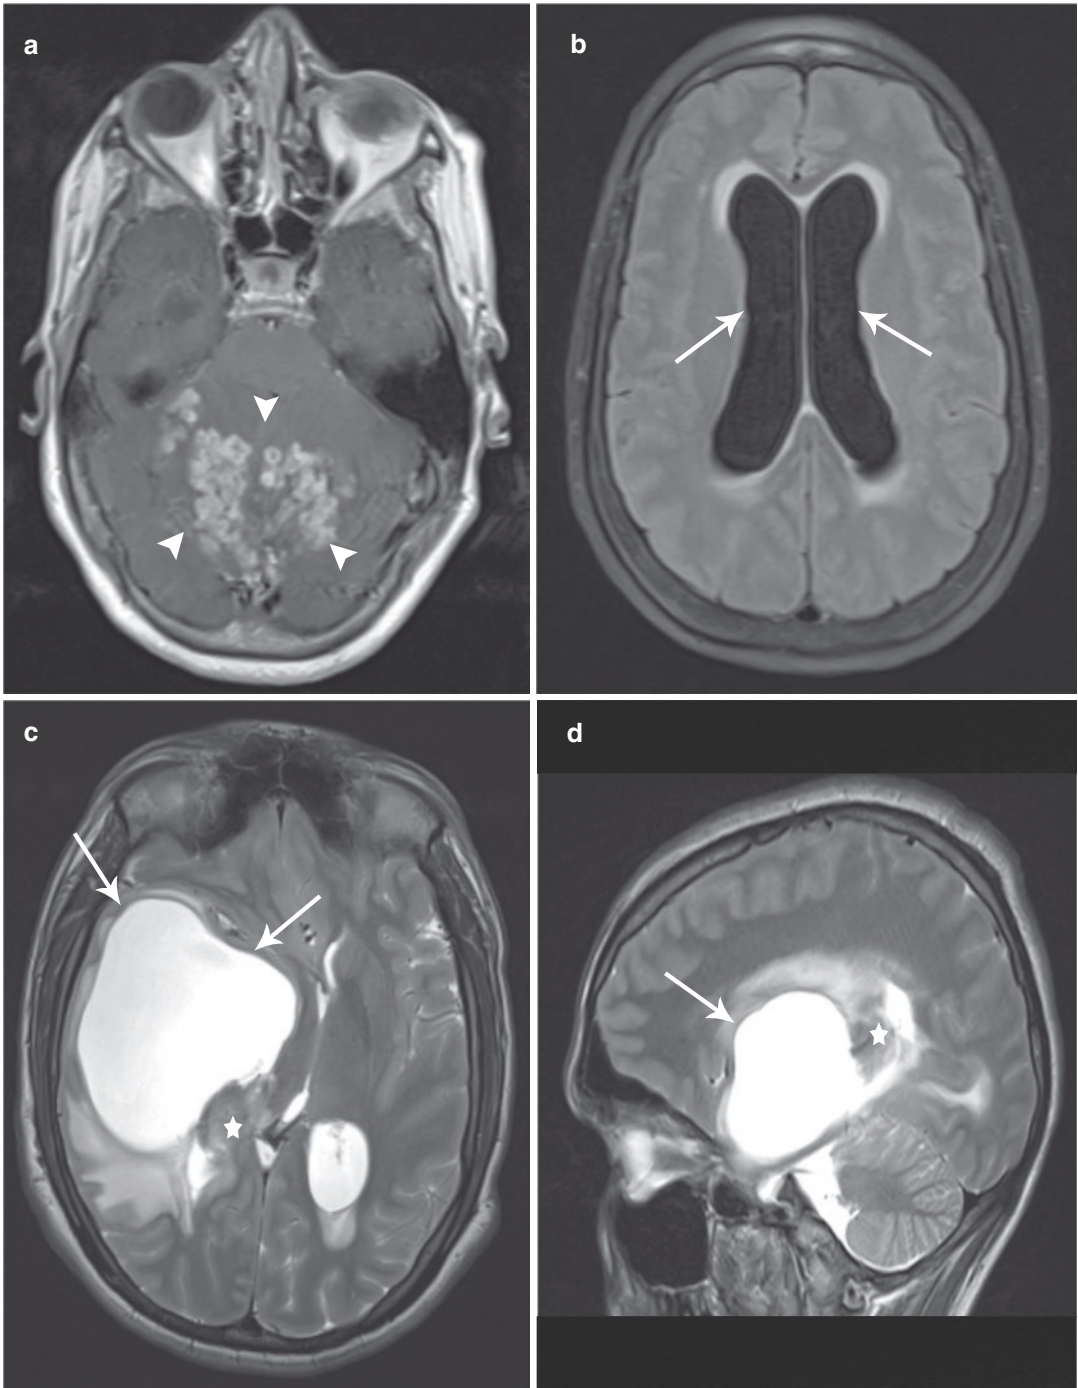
Obstructive hydrocephalus due to tuberculoma. Axial (a) contrast-enhanced T1-W and (b) FLAIR MR images show a cluster of tuberculomas in the posterior fossa (white arrowheads) exerting a mass effect on the fourth ventricle with subsequent obstructive hydrocephalus
